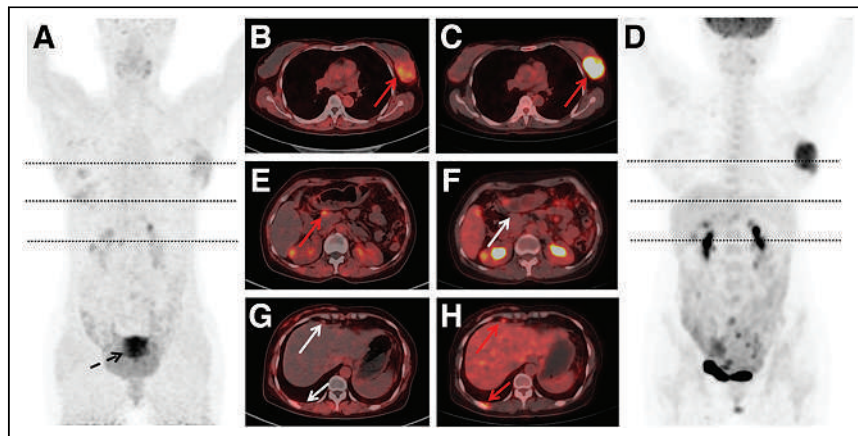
Images of ^{68}Ga -FAPI and ^{18}F -FDG PET/CT in 46-y-old woman with lymphoblastic leukemia/lymphoma. (A) Maximum-intensity projection of ^{68}Ga -FAPI PET. (B–H) Axial ^{68}Ga -FAPI PET/CT images (B, E, and G) and ^{18}F -FDG PET/CT images (C, F, and H). (D) Maximum-intensity projection of ^{18}F -FDG PET. Left breast involvement was detected with intense ^{68}Ga -FAPI and ^{18}F -FDG uptake (B and C, arrows). PET/CT image showed lesion with focal ^{68}Ga -FAPI uptake in pancreas (E, arrow) and normal ^{18}F -FDG activity (F, arrow). ^{18}F -FDG PET/CT image showed lymph nodes positive for uptake in internal mammary and subpleural areas (H, arrows), without corresponding ^{68}Ga -FAPI uptake (G, arrows). Intense ^{68}Ga -FAPI uptake was noted in uterus (A, arrow).
